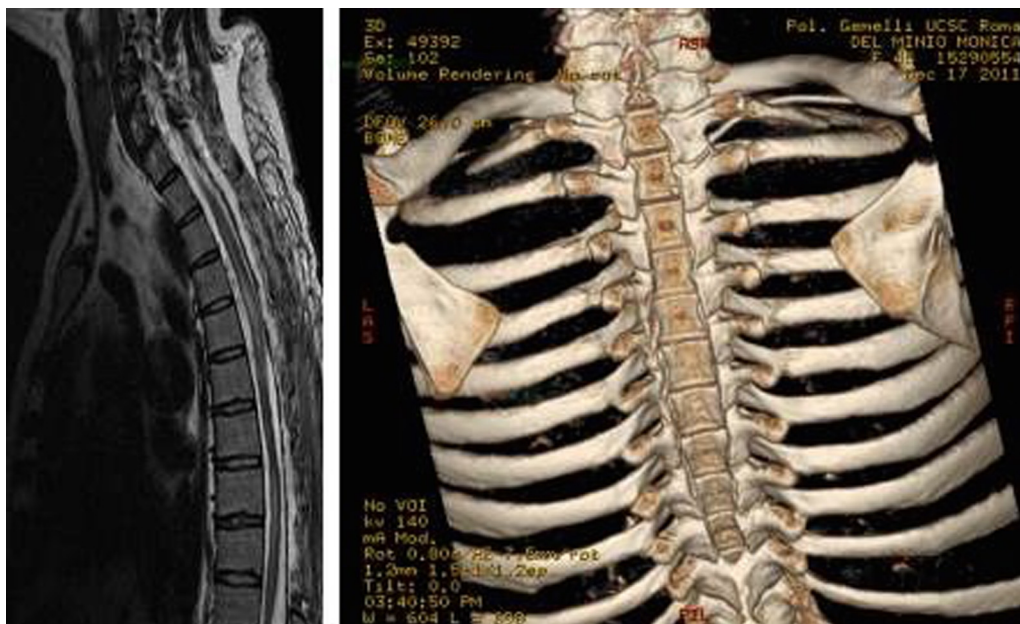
(Left) Sagittal T2 MR reconstruction (late follow up) showing T1–T10 cord decompression along with diffuse lesional pattern signal from Th3 to Th 10. (Right) 3D CT scan reconstruction showing the extension of laminectomy (C7) Th1–Th 10.
